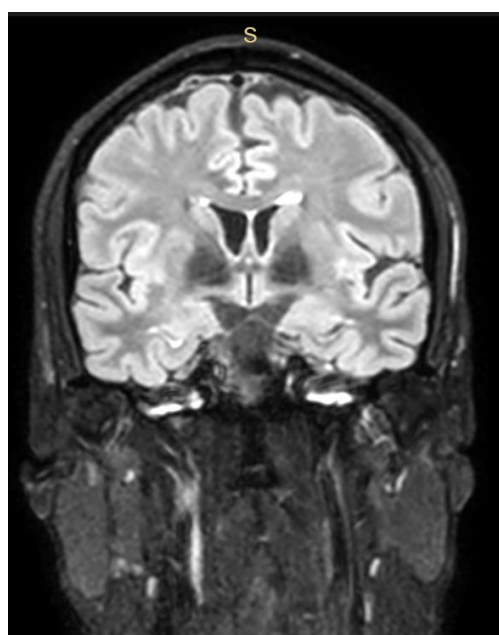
Brain MRI - coronal
